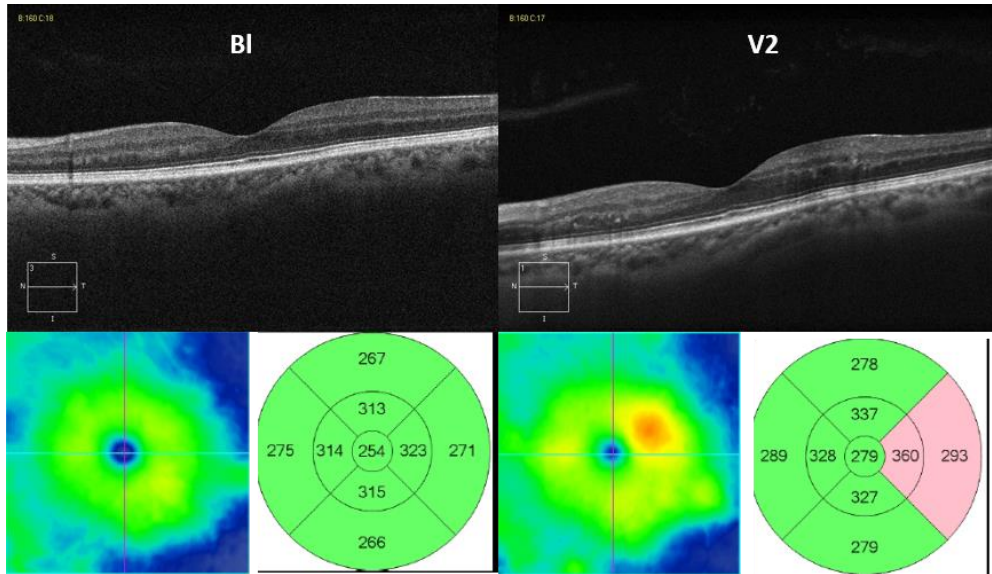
Choroidal morphologic changes in Retinal worsening progression. On baseline image (left) we can observe the loss of the inverted dome shape of SCI, with scarce great vessels with focal loss (nasally and just temporally to the center). One year later, in V2 (right) there was a moderate focal increase in RT (Retinal thickness maps below the line scan images) and outer retinal layers changes nasally. These changes are above the choroidal changes observed on BL, which persist and are more evident. The CT increase from 243μ to 252μ .
